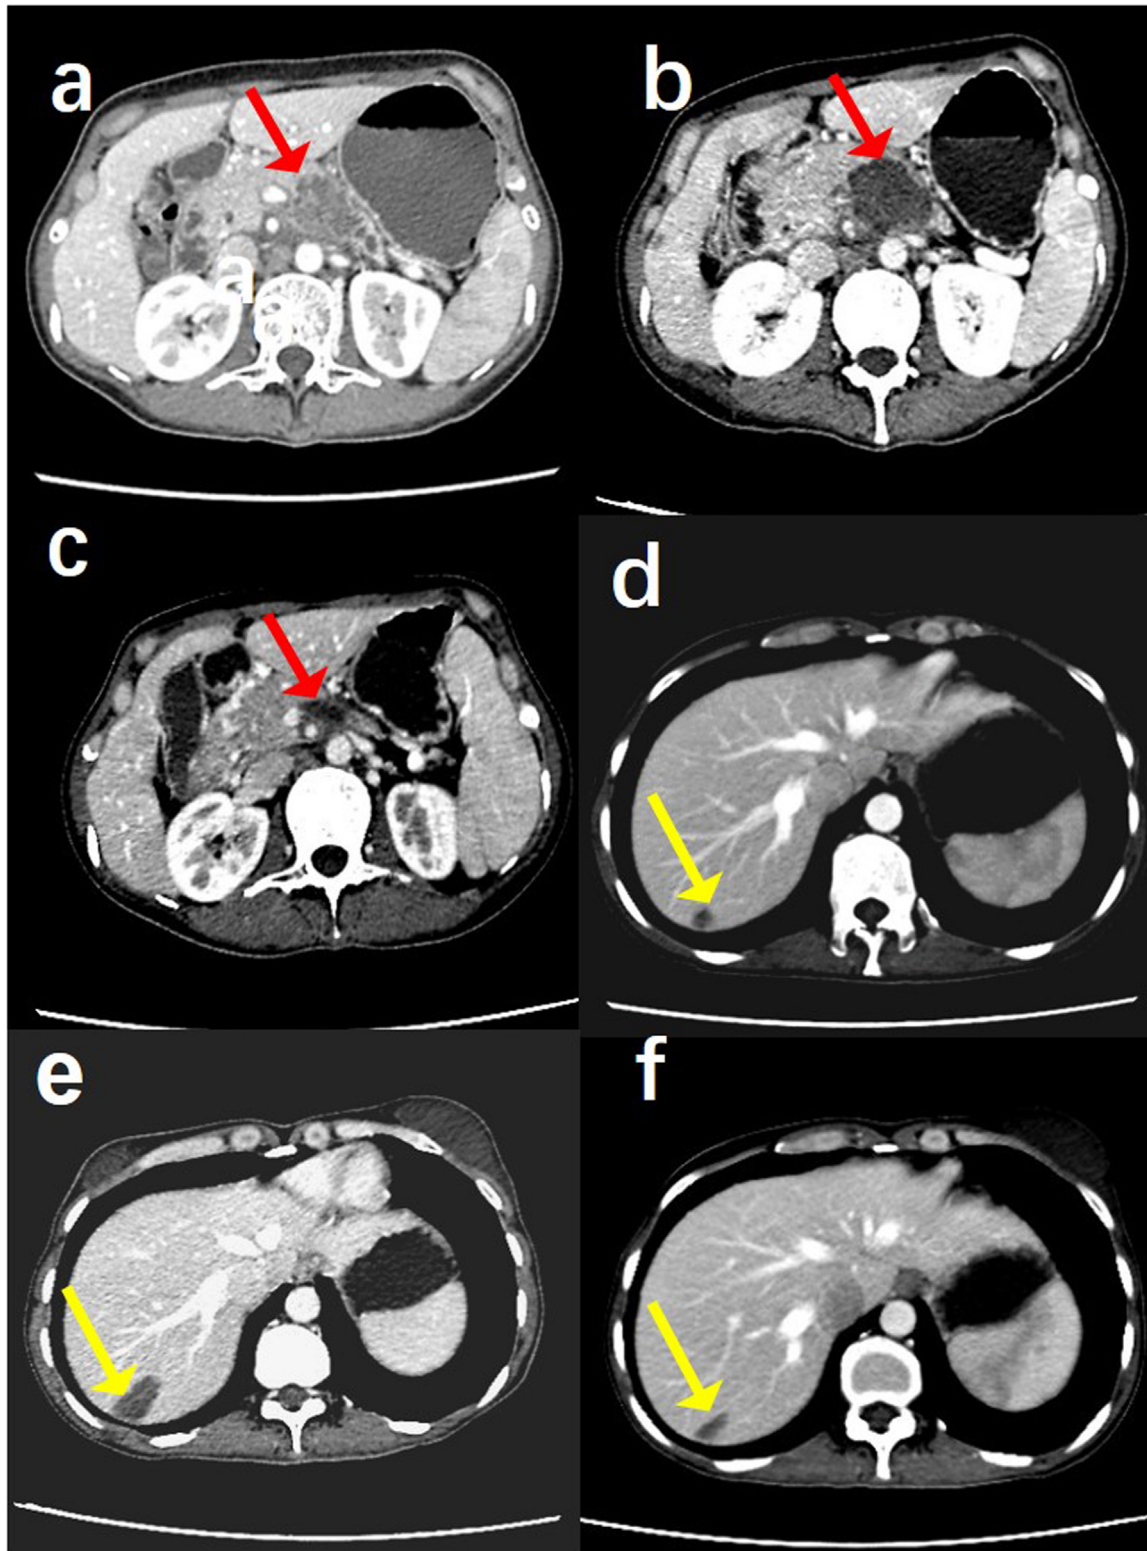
The changes in contrast-enhanced CT images before and after HIFU treatment in a 41-y-old female patient with advanced pancreatic carcinoma (UICC stage IV). (a) Before HIFU treatment, the enhanced CT image shows the tumor located in the body and tail of the pancreas (red arrow). (b) One week after HIFU, no contrast enhancement is seen in the treated tumor (red arrow). (c) Six months after HIFU, the enhanced CT image shows significant shrinkage of the treated tumor (red arrow). (d) Before HIFU treatment, the image shows one liver metastasis (yellow arrow). (e) One week after HIFU, the metastatic liver tumor is effectively ablated with no contrast enhancement in the enhanced CT image (yellow arrow). (f) Six months after HIFU, significant shrinkage of the treated liver metastasis is evident (yellow arrow).
